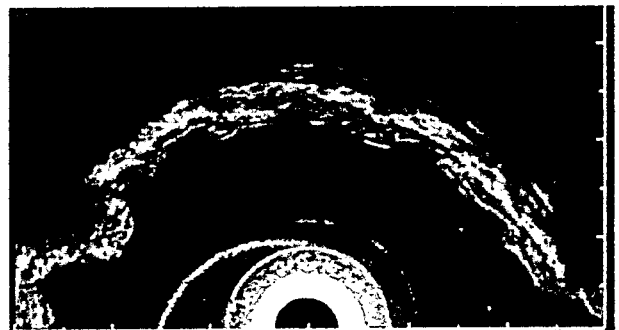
Endoscopic ultrasonography images in the greater curvature of the gastric body with a nodular appearance. There was uneven thickening of the second hypoechoic layer
